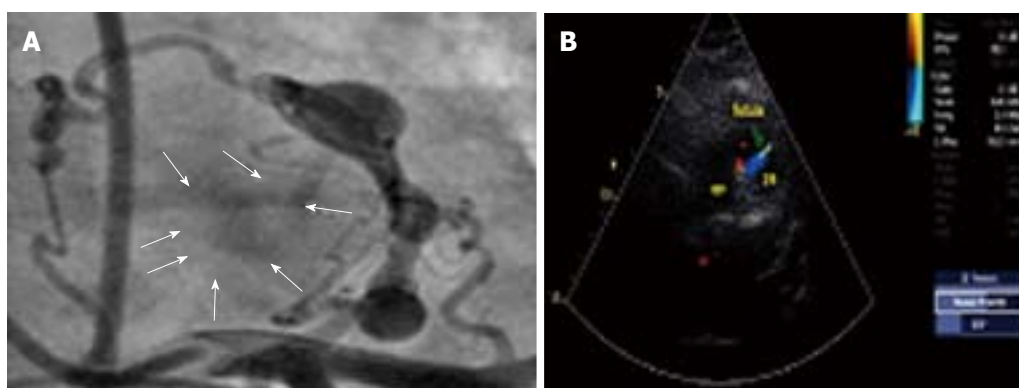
The passage of the contrast agent formed by the fistula (A), parasternal short axis echocardiography revealed the color flow associated with the fistula (B).
